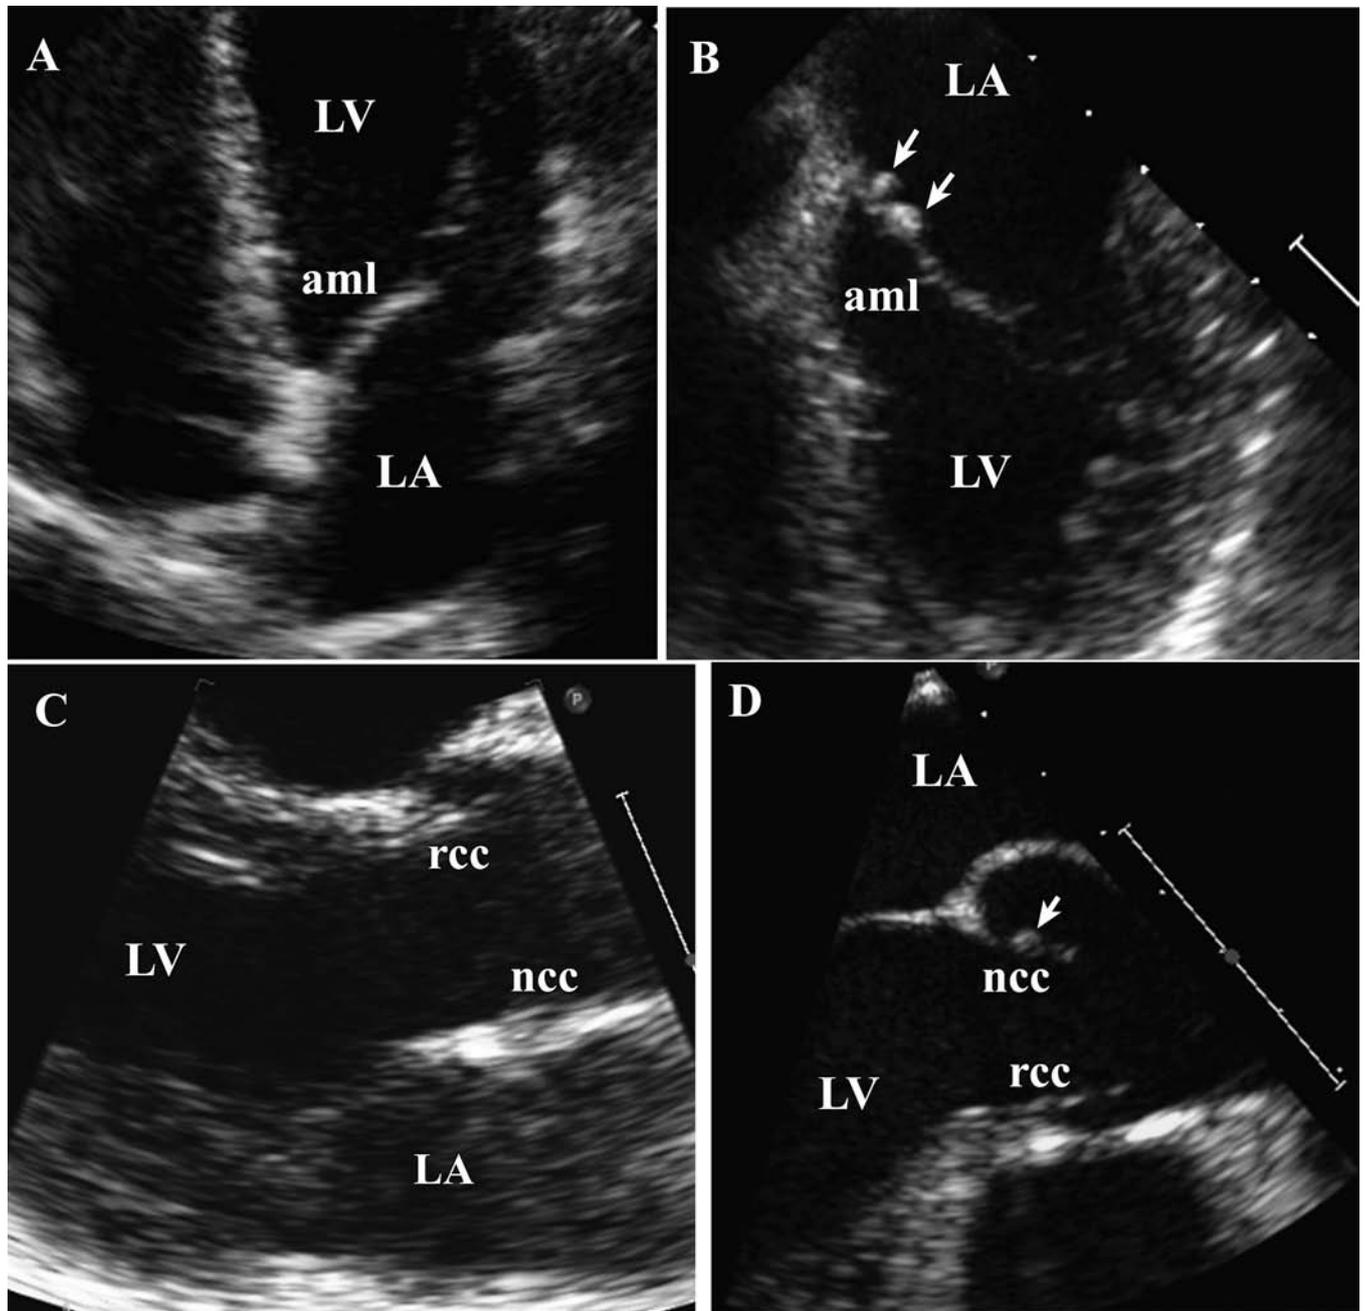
Detection of Libman-Sacks endocarditis by transthoracic and transesophageal echocardiography. A. TTE 4-chamber view in a young patient with SLE and a recent transient ischemic attack shows diffuse thickening of the anterior mitral leaflet (aml), but no vegetations. B. In contrast to (A), this TEE 4-chamber view shows normal thickness of the aml, but 2 small sessile vegetations located at the base and atrial side of the aml (arrows). Associated mild mitral regurgitation was shown by both techniques. C. This TTE parasternal long-axis view in an asymptomatic young patient with SLE shows mild thickening of the aortic right coronary cusp (rcc) and a normal appearing noncoronary cusp (ncc). D. In contrast to (C), this TEE view longitudinal to the left ventricular outflow tract shows a normal-appearing aortic rcc, but an abnormal ncc with a small vegetation located in the mid-portion and aortic side of the cusp (arrow), with associated mild thickening. Neither technique demonstrated aortic regurgitation. The different location of the aortic valve cusps is due to the anteroposterior imaging plane by TTE and posteroanterior imaging plane by TEE. LA: left atrium, LV: left ventricle.
